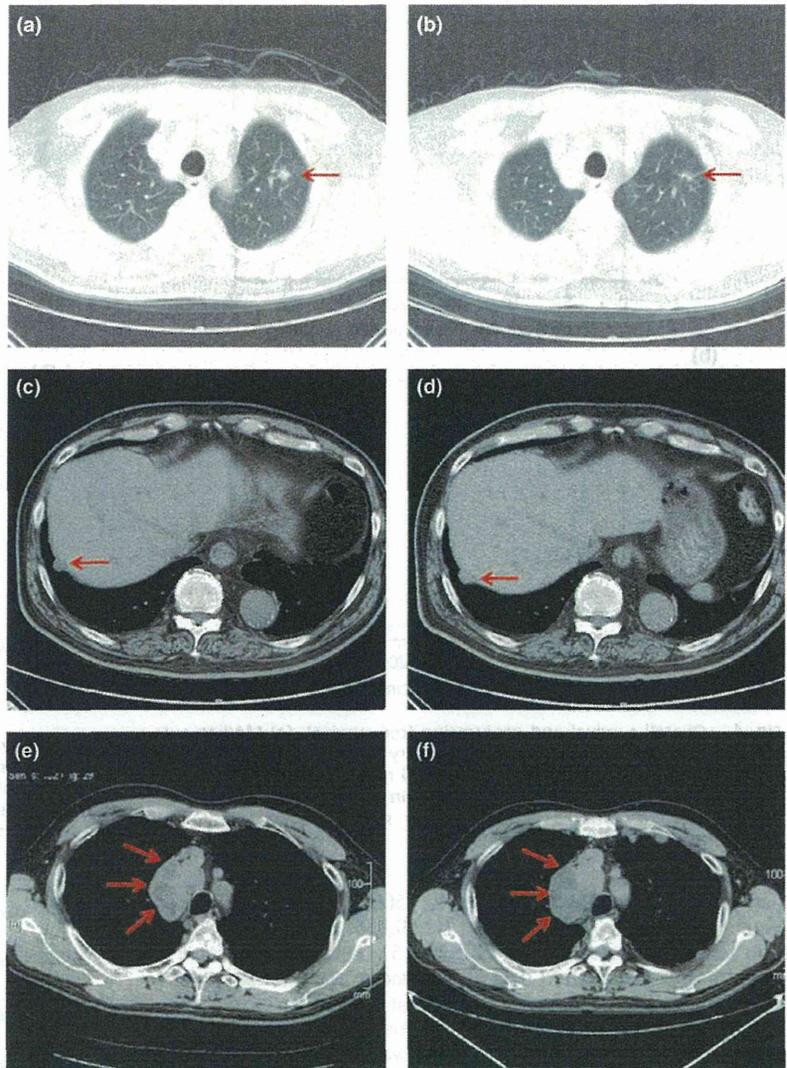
Clinical responses to personalized peptide vaccination (PPV). (a–d) Computed tomography findings of one of stable disease (SD) cases before and after the 6th vaccination. At 4 months after the first vaccination, the lung metastasis was remarkably reduced in size, but the liver metastasis showed no changes in size. (e,f) Computed tomography findings of another SD case before and after the 6th vaccination. A huge mediastinal tumor showed no increase in size for a period of 34 months after the first vaccination.
